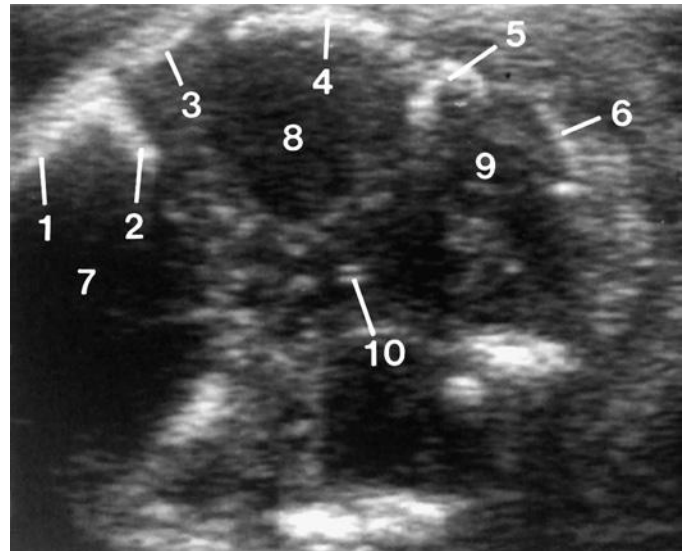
Transverse axial sonogram near the skull base. 1, frontal bone; 2, greater wing of sphenoid bone; 3, parietal bone; 4, temporal bone; 5, petrous ridge; 6, occipital bone; 7, anterior cranial fossa; 8, middle cranial fossa; 9, posterior cranial fossa; 10, basilar artery.
